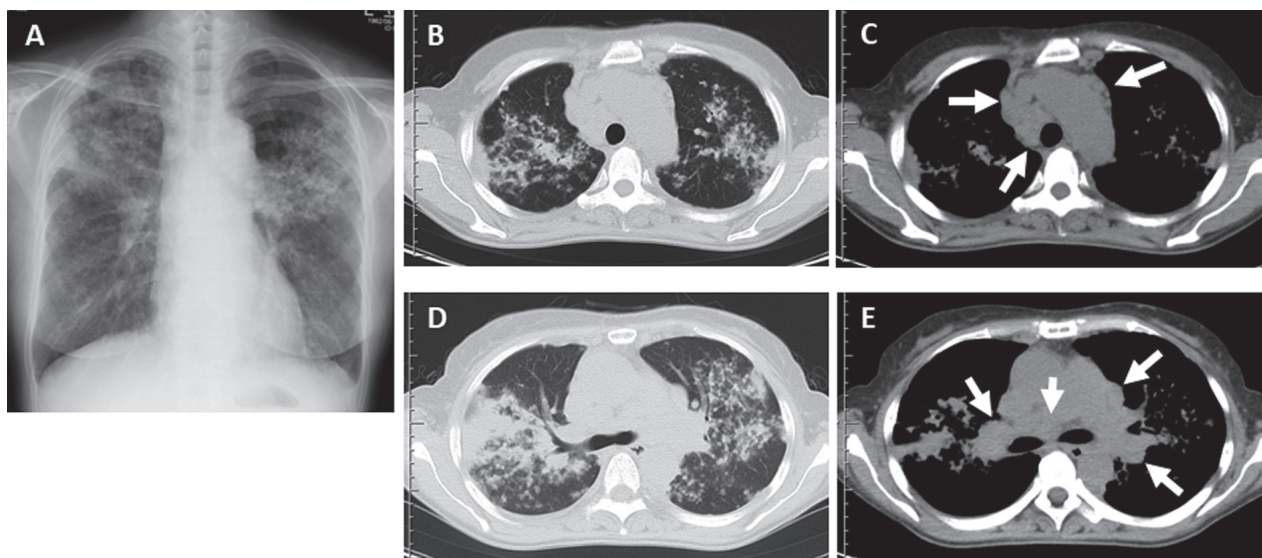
Chest X-ray (A) and computed tomography (CT) imaging (B-E) at first visit. CT scan revealed multifocal ill-defined densities and thickening of bronchial wall and pulmonary vessels by fine nodules (B, D). Arrows indicate massive enlargement of bilateral mediastinal and hilar lymph nodes (C, E)
